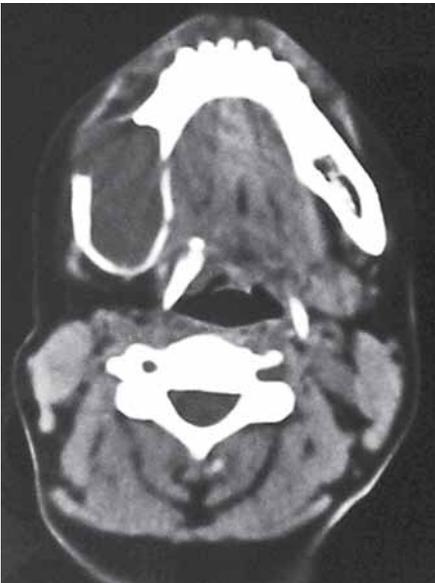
Axial CT image showing cystic lesion in right mandible with thinning and loss of cortices
